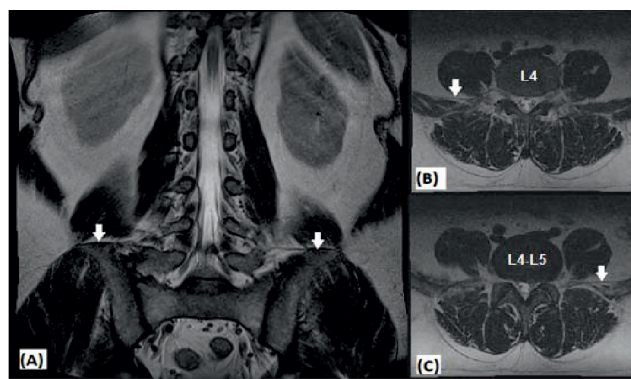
Clockwise - MRI images of (A) T2W coronal section of LSTV spine with sacralization (Castellvi type 2a); (B) T2W axial section of spine shown in (A) at L4 showing right ILL arising from L4; and (c) T2W axial section of spine shown in (a) at L4-L5 showing left ILL arising from L5.
